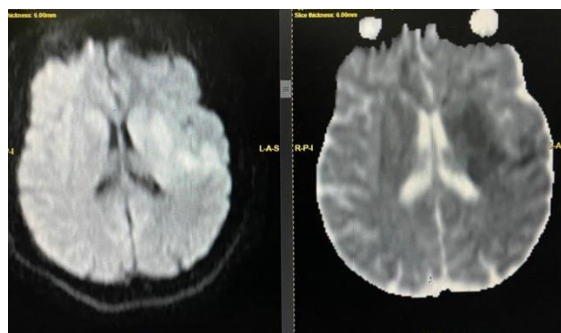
MRI Showing Acute infarct
